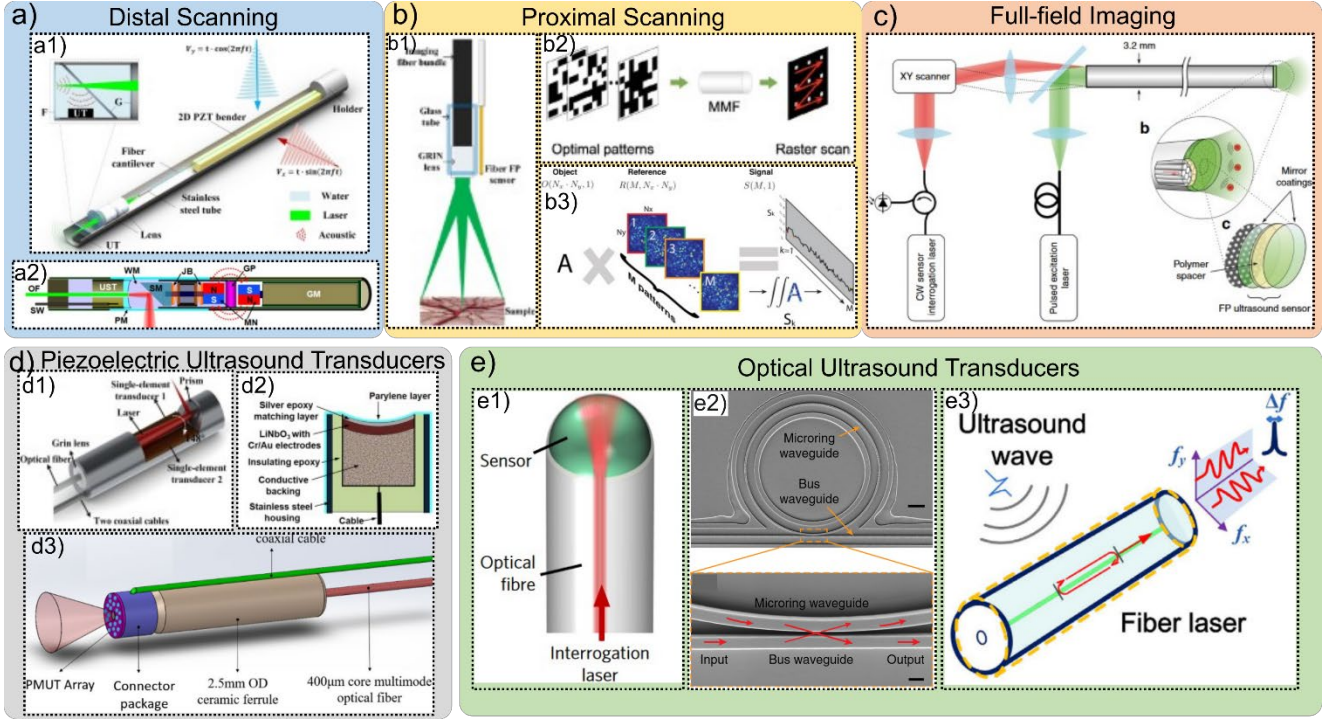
Examples of the two key components in existing endoscopic PAM devices: light delivery (a)-(c) and ultrasound detection (d)-(e). (a) Distal scanning: a1) fiber catheter⁶⁴; a2) rotor¹⁰¹. Reprinted with permission from [64] Copyright 2024 AIP Publishing. Reprinted with permission from [101] Copyright 2024 Optica Publishing Group. (b) Proximal scanning: b1) core-by-core scanning over a multi-core fiber⁵⁸; b2) wavefront shaping⁷²; b3) speckle illumination⁷¹. Reprinted with permission from [58] Copyright 2024 IEEE. Reprinted with permission from [72] Copyright 2024 Elsevier. Reprinted with permission from [71] Copyright 2024 AIP Publishing. (c) Full-field imaging based on an ultrasound array⁸¹. Reprinted with permission from [81] Copyright 2024 Springer Nature. (d) Piezoelectric ultrasound transducers: d1) unfocused transducer⁴²; d2) focused transducer¹⁰²; d3) PMUT transducer array⁸². Reprinted with permission from [42] Copyright 2024 Optica Publishing Group. Reprinted with permission from [82, 102] Copyright 2024 SPIE. (e) Optical ultrasound sensors: e1) fiber Fabry-Pérot sensor¹⁰³; e2) microring resonator¹⁰⁴; e3) fiber laser¹⁰⁵. Reprinted with permission from [103-105] Copyright 2024 Springer Nature.
